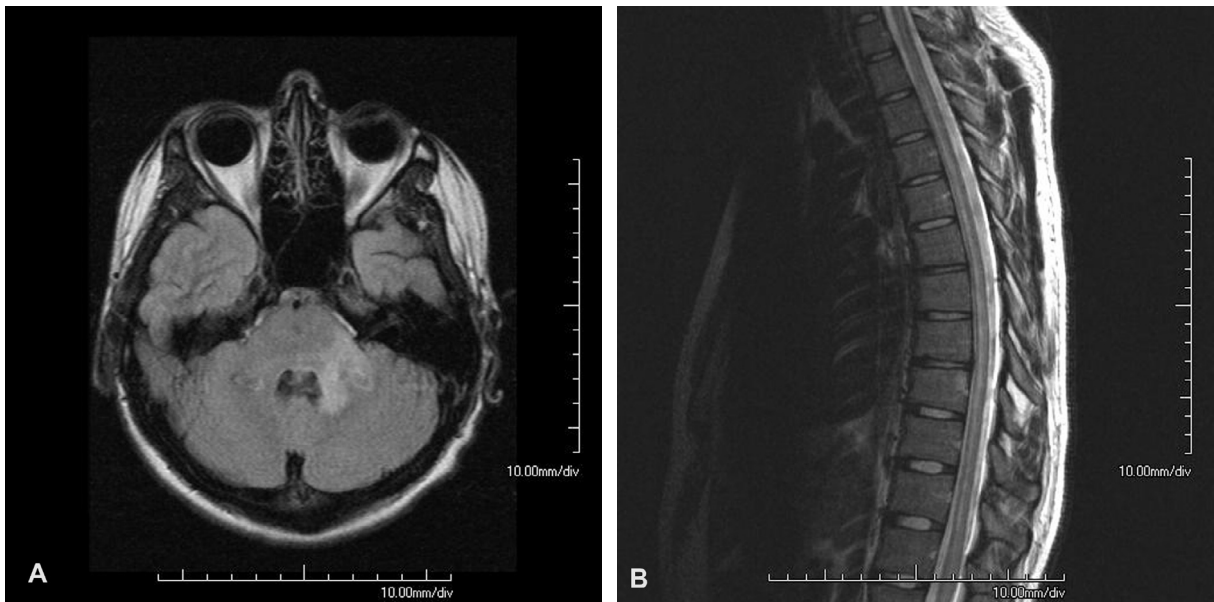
(A) Magnetic resonance image (MRI) of the brain showing areas of high signal intensity on fluid attenuation inversion recovery (FLAIR) in the left middle cerebellar peduncle and right dorsal medulla oblongata. (B) T2-weighted magnetic resonance image (MRI) shows an extensive multilevel linear area of high signal intensity along the cervicothoracic spinal cord.
